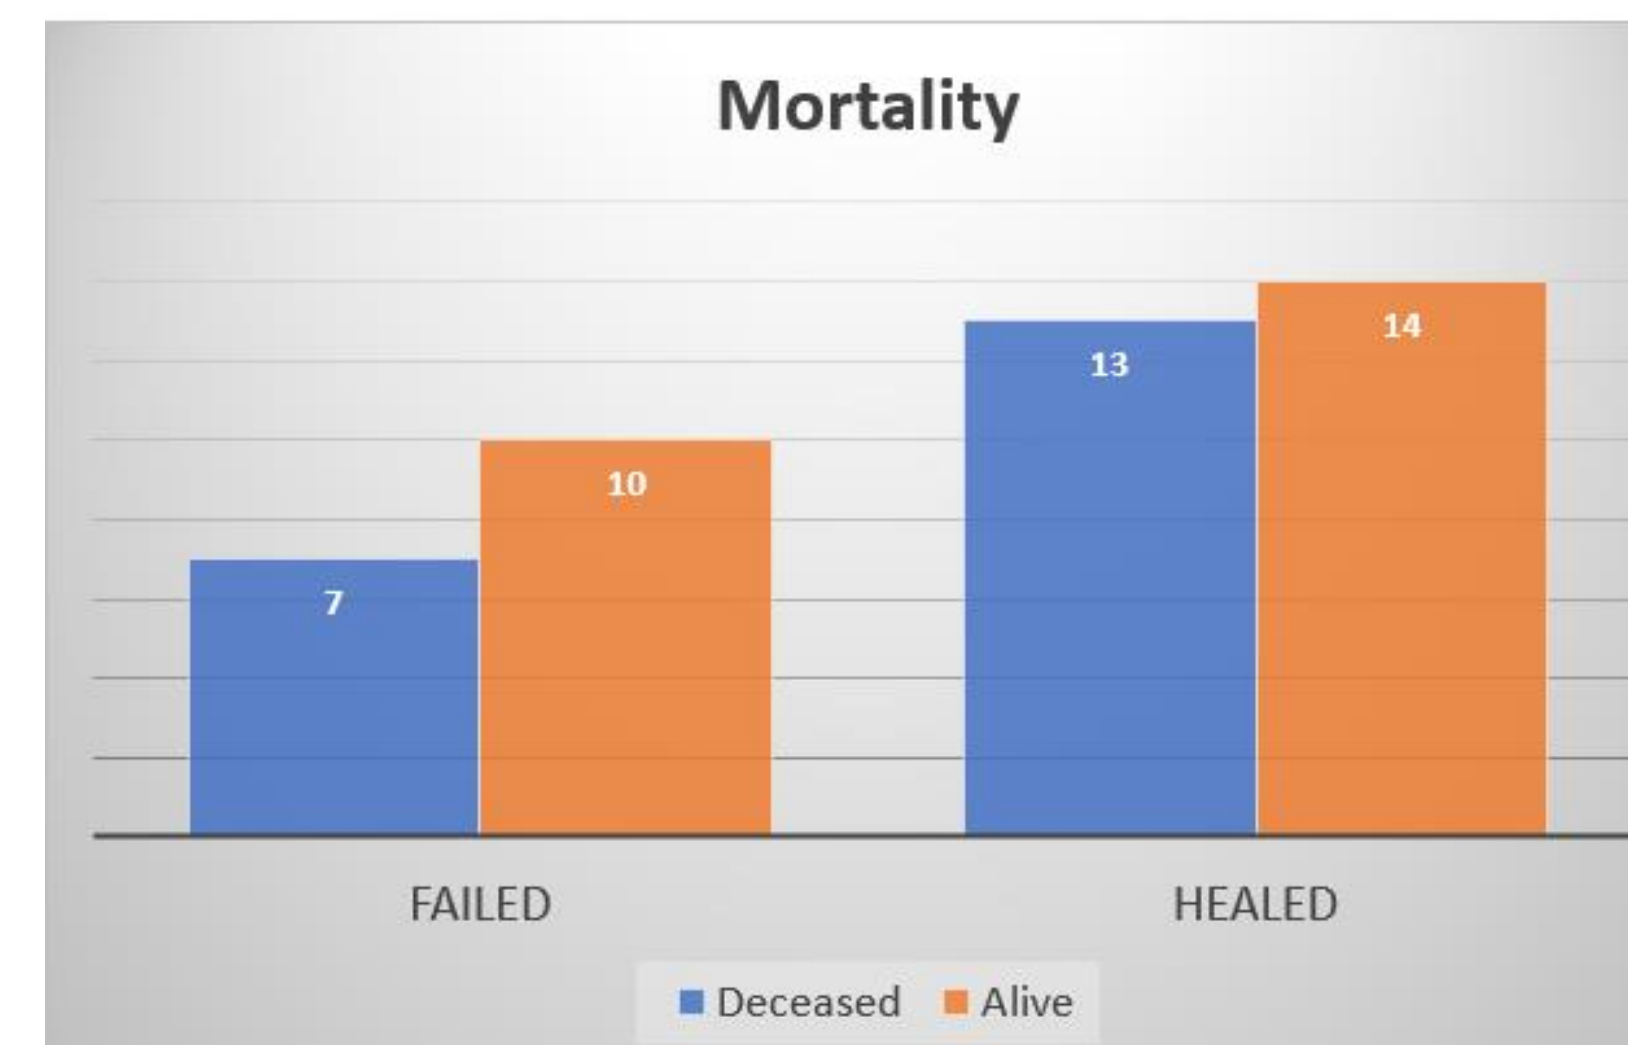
Overall survival rate of patient with TMA and had angiogram/CTA.
